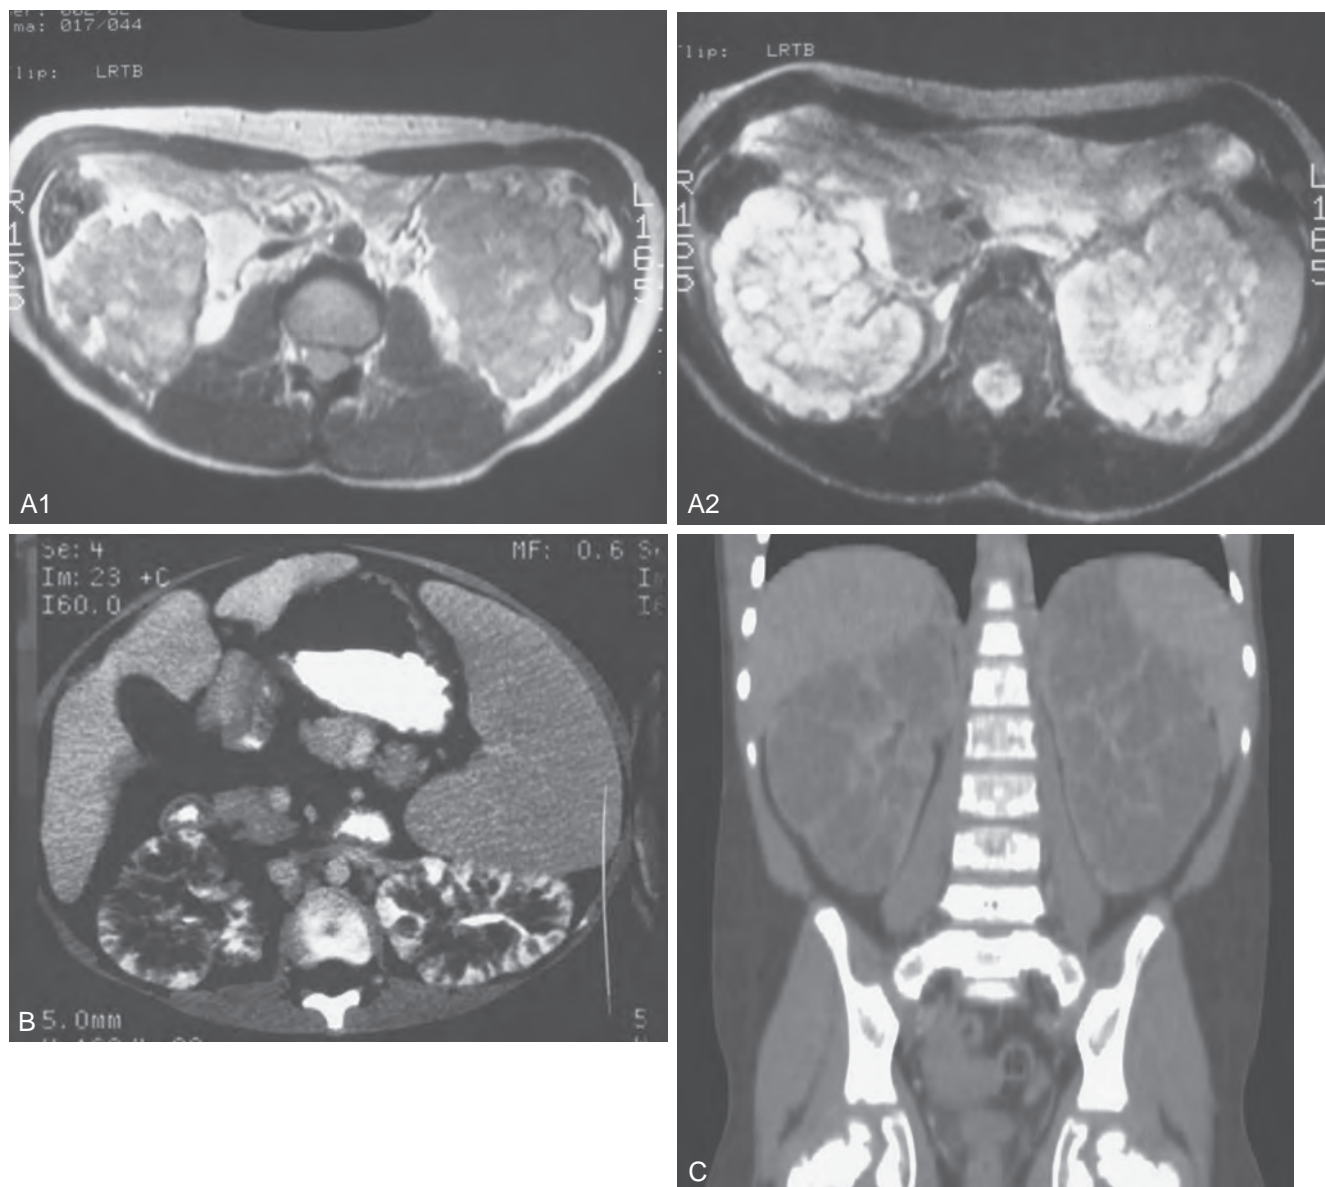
A1 and A2, Magnetic resonance images of an 8-month-old child with autosomal recessive polycystic kidney disease (ARPKD) demonstrating multiple renal cysts. A1, On T1-weighted image, fluid content of cysts appears dark. A2, On T2-weighted image, the fluid content appears white. B, Computed tomography scan of a child with ARPKD. Horizontal cuts showing contrast puddling in collecting ducts. C, Coronal cut. Note that the kidneys are enlarged and the enhancing renal parenchyma is effaced by nonenhancing cysts and represents the progression and normal history of the disorder. (A, Courtesy Walter Berdon, MD; B, courtesy Marta Hernanz-Schulman, MD.)
